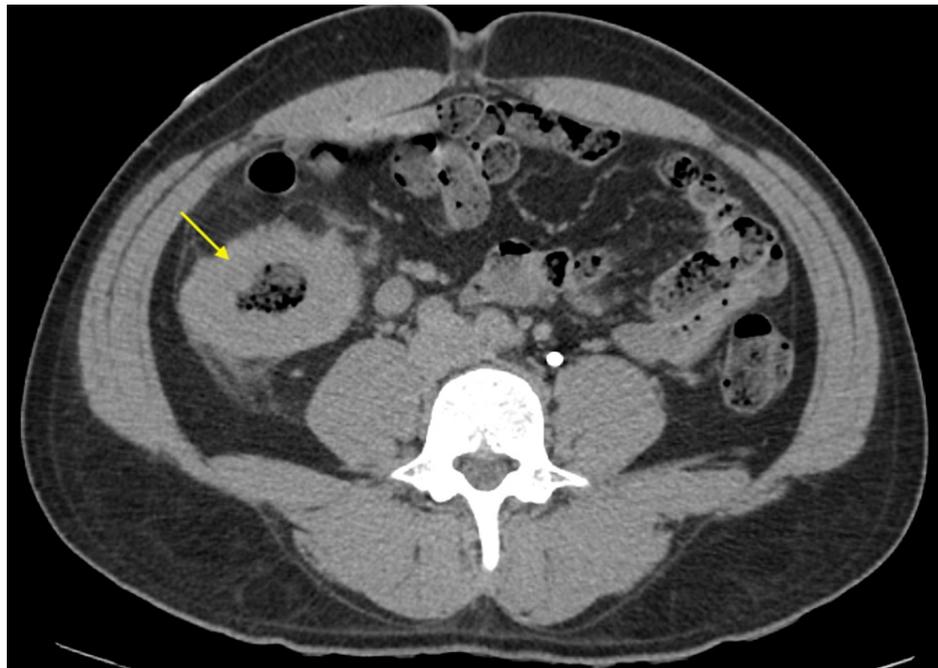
CT abdomen and pelvis with contrast shows a circumferential wall thickening of the proximal ascending colon with prominent lymph nodes (arrow).
